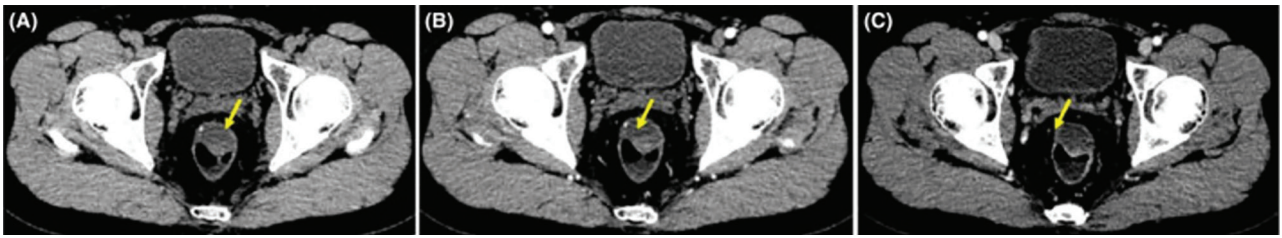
Contrast-enhanced CT. (A) A quasi-circular low-density focus is visible on the plain scan, with smooth rectal mucosa and an intact intestinal wall. (B, C) No enhancement is seen in the arterial and venous phases of the lesion. Image source: Jiang et al. (Reference 5); reused under the terms of the Creative Commons Attribution License <http://creativecommons.org/licenses/by-nc-nd/4.0/>
